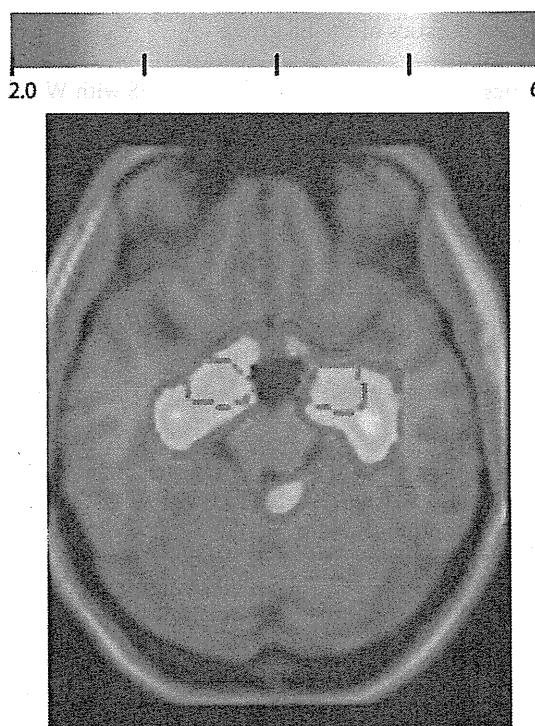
Z-score map overlaid on an MRI template of a representative patient with AD-aMCI made with VSRAD. This patient was included in the study because of the presence of significant atrophy in the entorhinal cortices on MRI. Parts of the colored areas are in the areas circumscribed by purple lines, indicating significant atrophy in the entorhinal cortices. Purple lines indicate the bilateral entorhinal cortices. Colored areas on MRI are those with a Z-score >2 (significant atrophy). Color bar indicates Z-score.
